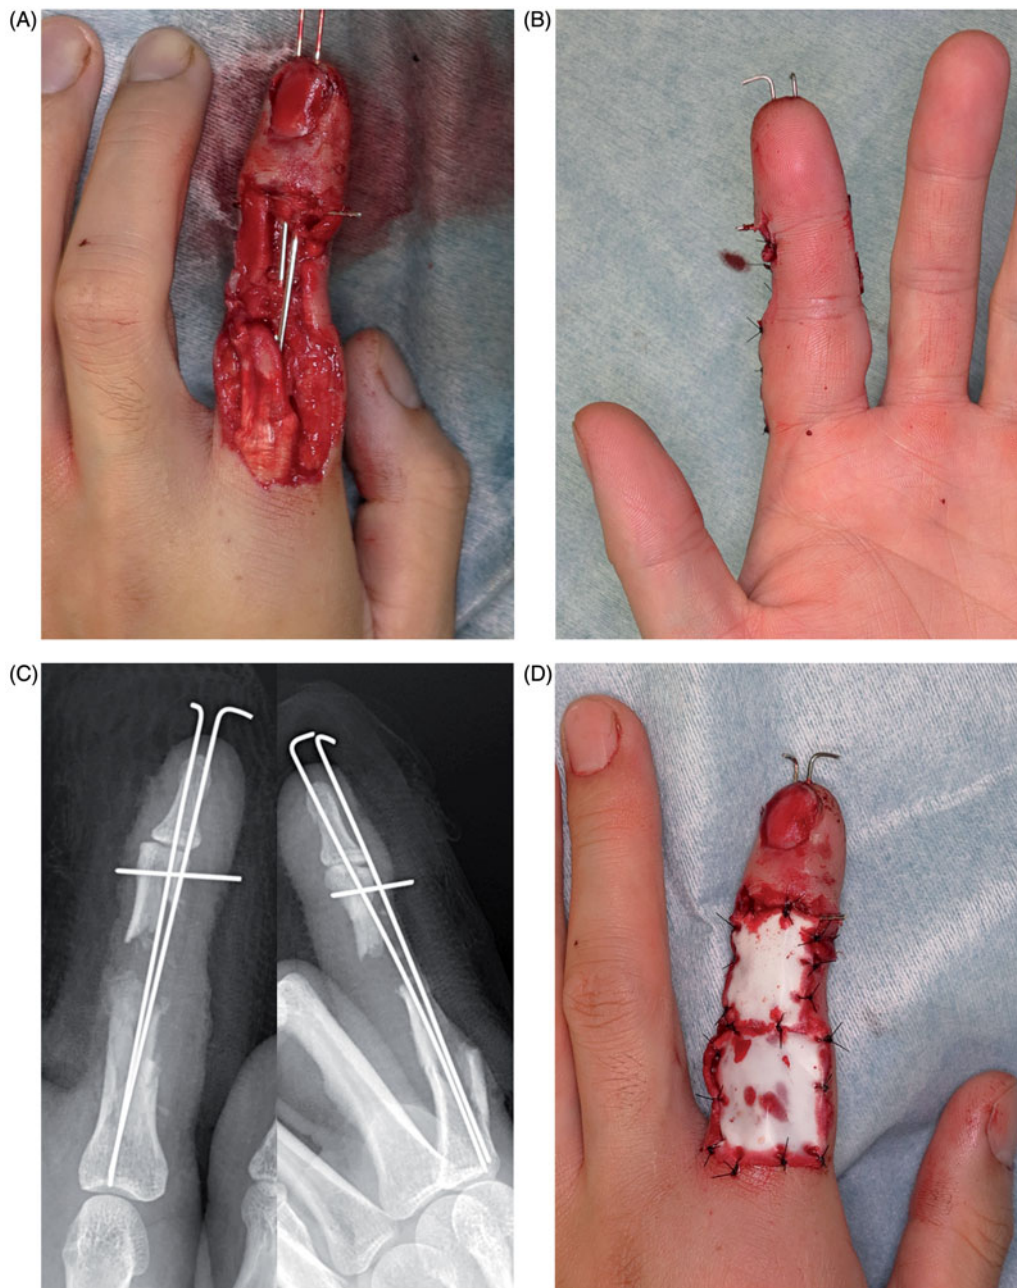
First operation in case 2. (A) Wire fixation of the remnant bone pieces. Defect of the expansion hood is apparent. (B) Original length of the index finger is preserved by wire fixation. (C) X-ray depicting bone defect. (D) Artificial dermis temporarily applied to cover the wound.
